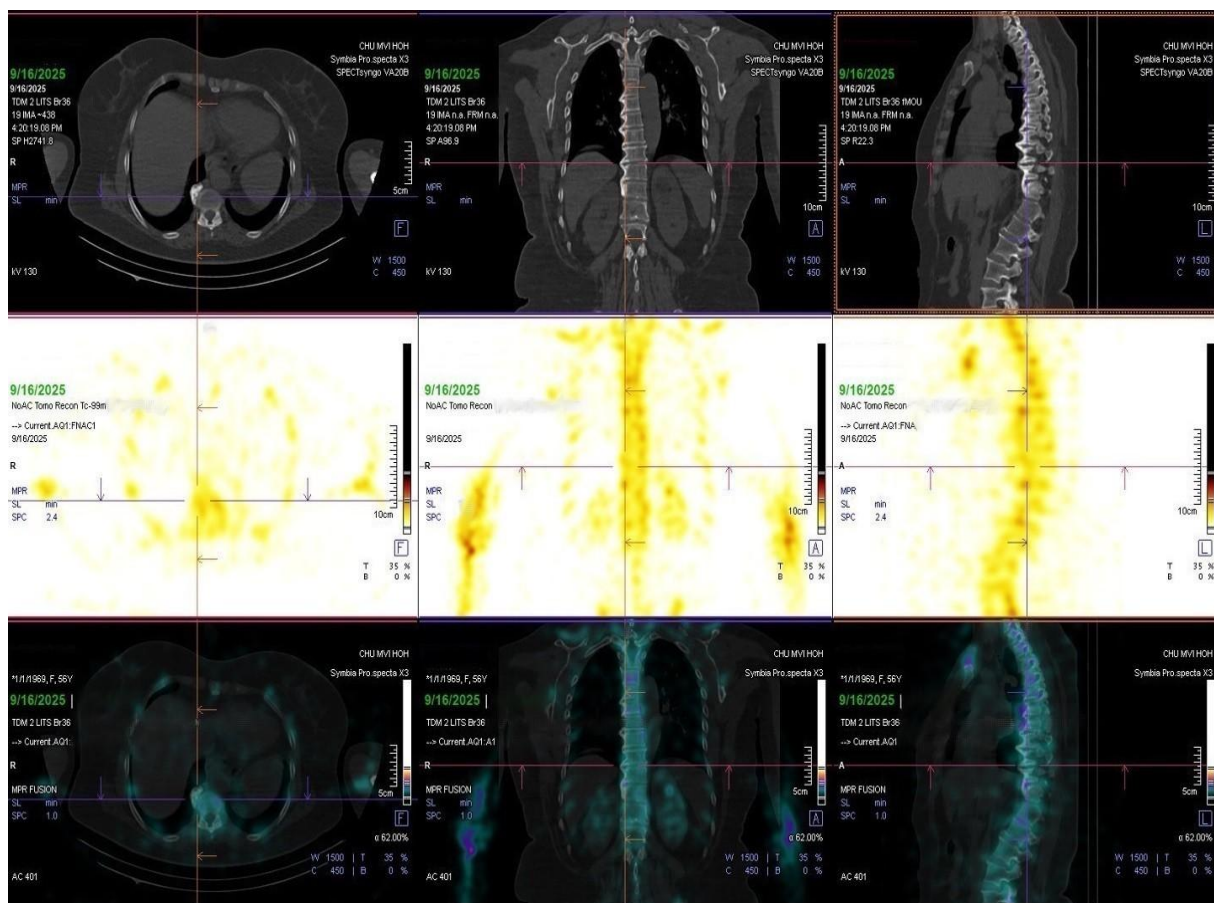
SPECT/CT acquisition of the thoracolumbar spine.
